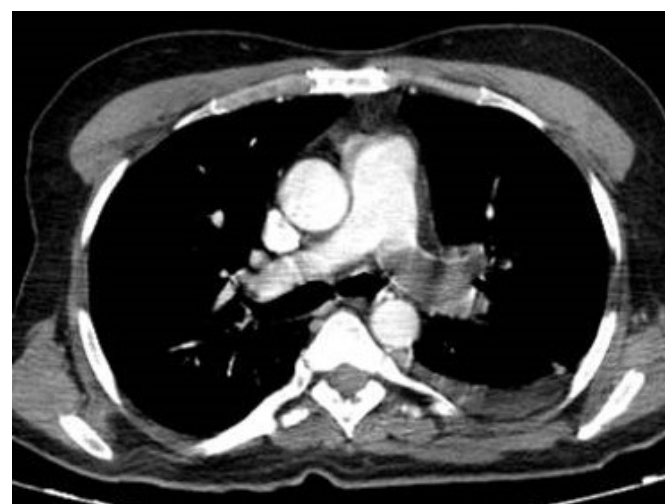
Pulmonary CT angiography of massive pulmonary thrombus in left main pulmonary artery.
